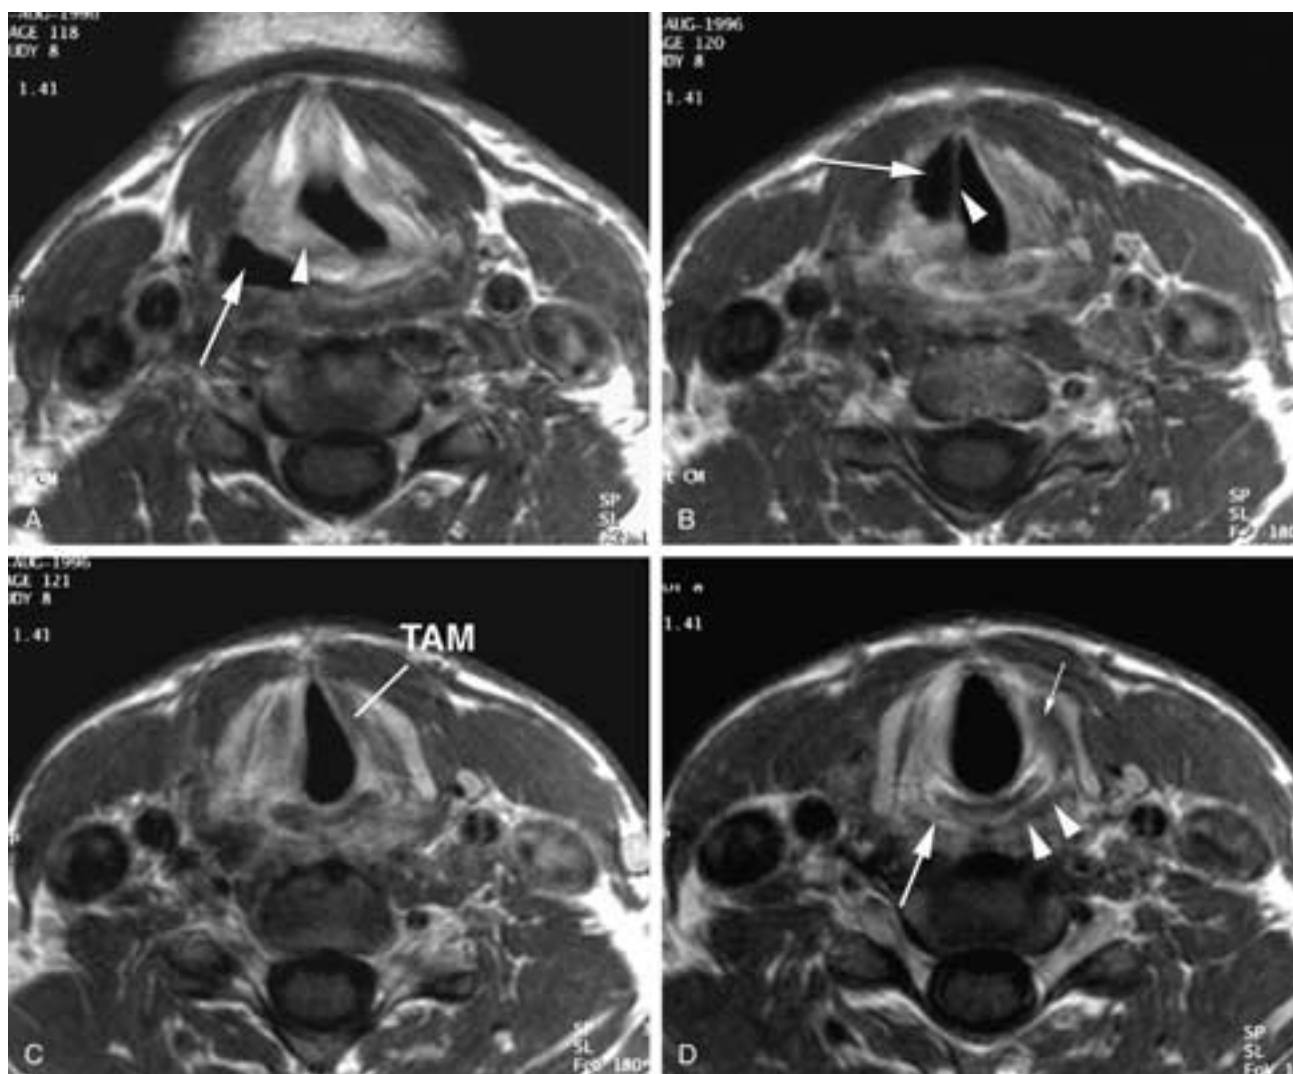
Vocal cord paralysis on the right side. MR image. A, Supraglottic level shows enlargement of the pyriform sinus (*arrow*) and anterior tilting of the AE fold (*arrowhead*). B, Level of the true cord. There is enlargement of the ventricle (*arrow*) as the TAM on the involved side atrophies. The vocal ligament (*arrowhead*) remains in place. C, The true cord on the left side shows a normal signal intensity. Thyroarytenoid muscle (*TAM*). D, Image slightly caudal to C shows the abnormal signal and decreased size of the posterior cricoarytenoid (*large arrow*) on the involved side. Compare with the bulk of the posterior cricoarytenoid muscle on the normal side (*arrowheads*). Anterior cricoarytenoid muscle on the normal side (*small arrow*).
